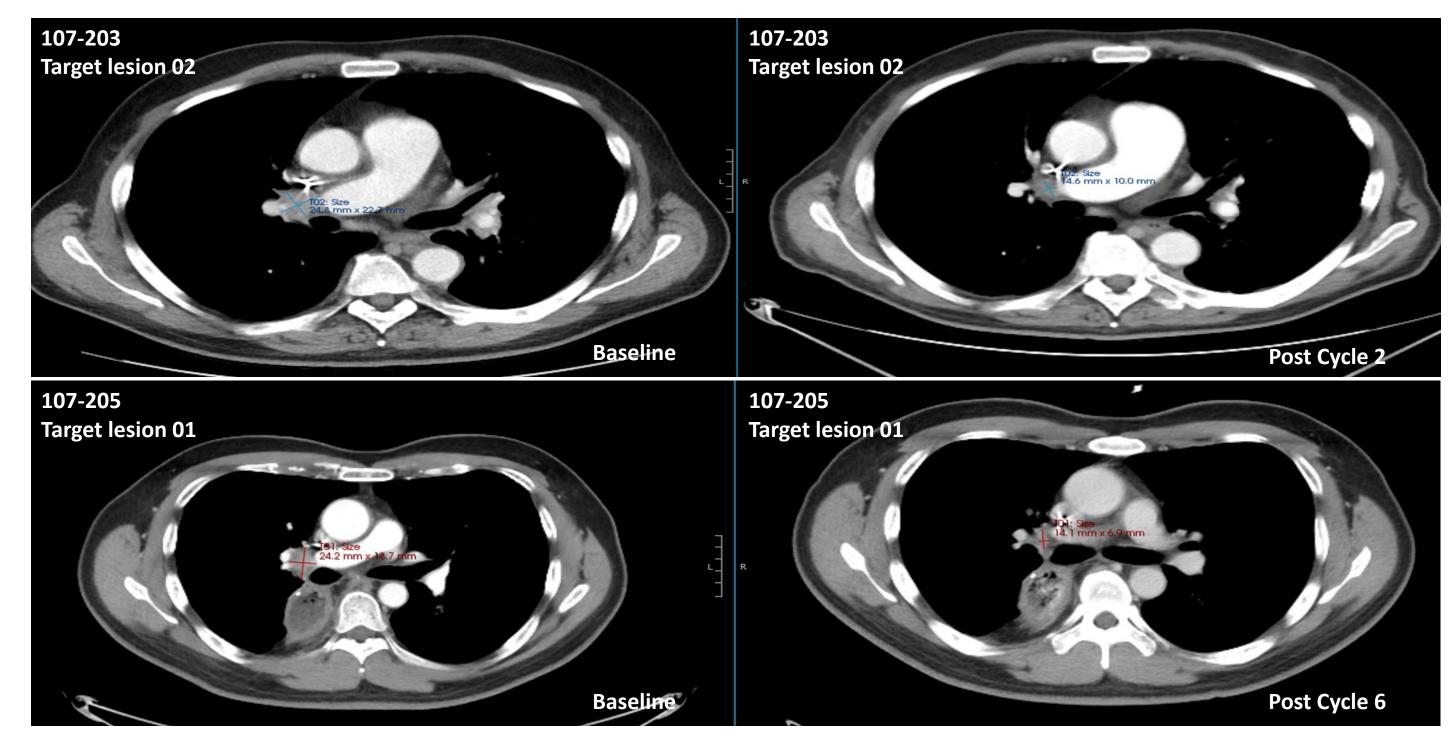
CT scans from baseline (left) and on-treatment (right) for 2 patients
